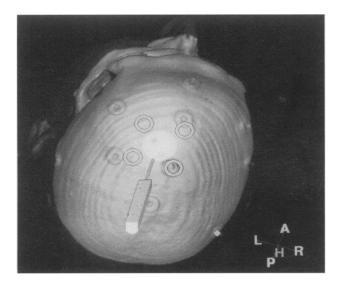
Advanced interactive craniotomy planning: a three dimensional segmentation has been generated (bone from CT) and a small superficial right frontal meningioma marked as a volumetric ellipse. After registration the pointer position is dynamically displayed in three dimensions, enabling the surgeon to exactly trace the contours of the tumour and effecting a small, minimally invasive craniotomy that is highly accurate, thus minimising brain manipulation.
